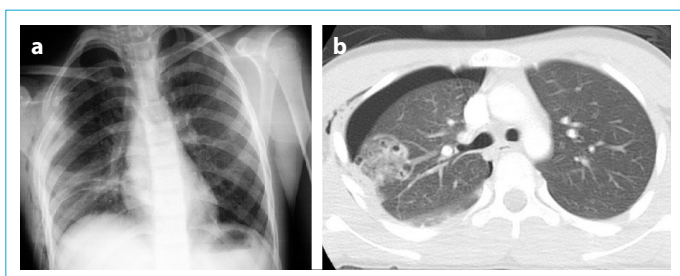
(a) 14 years old boy admitted to the emergency room after trauma. There were bilateral pneumothorax, bone fractures, subcutaneous emphysema and ground glass opacities in chest X-ray. (b) On chest CT, there were additional findings according to chest X-ray such as parenchymal laceration and contusion.
